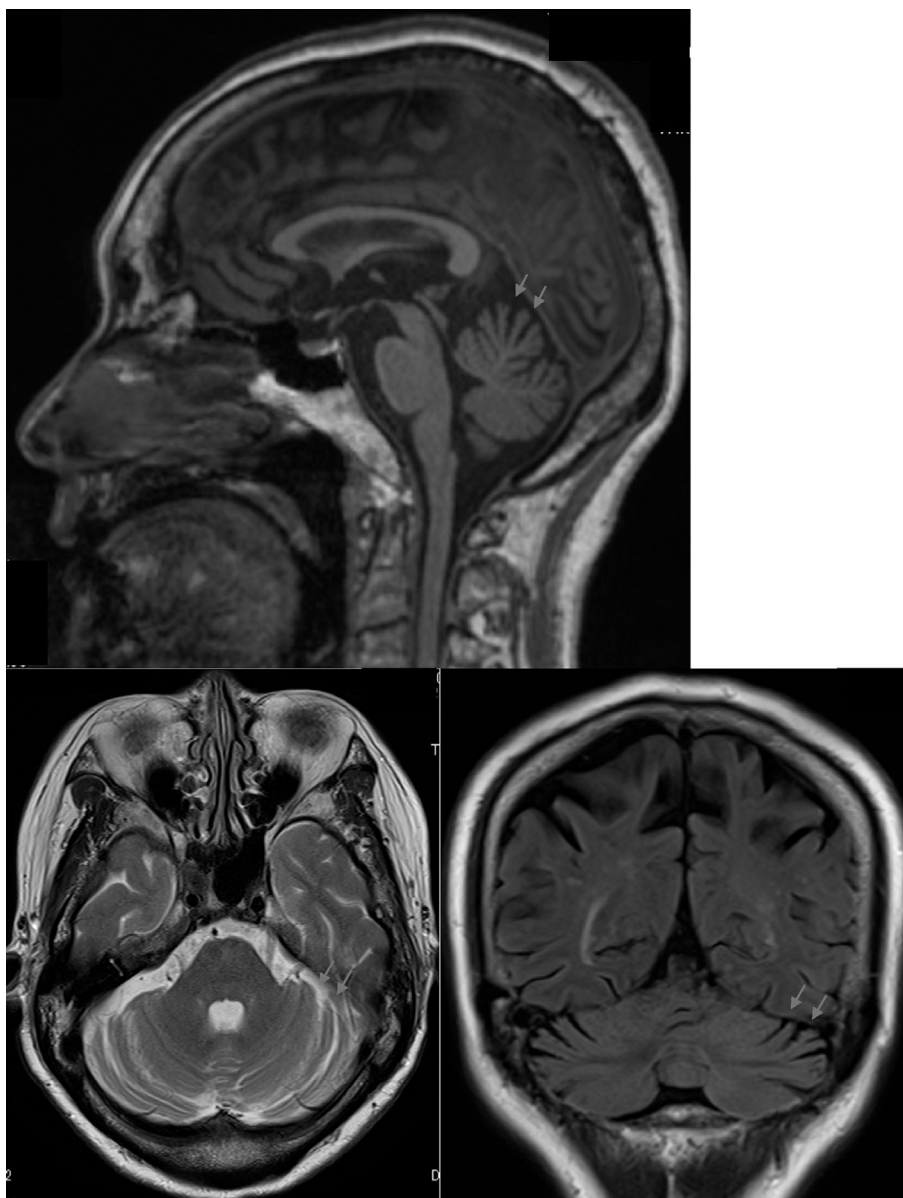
Brain MRI findings of the patient two years after the urodynamic tests. Axial, sagittal and coronal planes of T2-weighted 3T MRI showed atrophy in the cerebellar vermis and cerebellar hemisphere (arrows), although midline linear hyperintensity or middle cerebellar peduncle hyperintensity was not observed. She had no parkinsonism.
